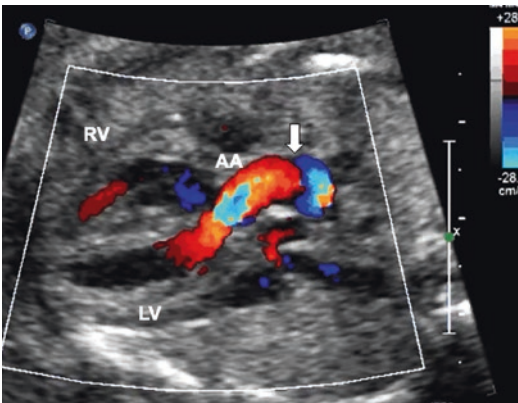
Doppler color flow depiction of change in the direction of flow. The image shows Doppler color mapping of flow through the ascending aorta (*AA*) and the arch of the aorta. In the ascending aorta, the flow is toward the transducer and is therefore depicted as *red* according to the color bar setting. As the direction of flow changes, the color becomes *blue* with a dark line separating the two hues (vertical arrow). *LV* Left ventricle, *RV* Right ventricle
